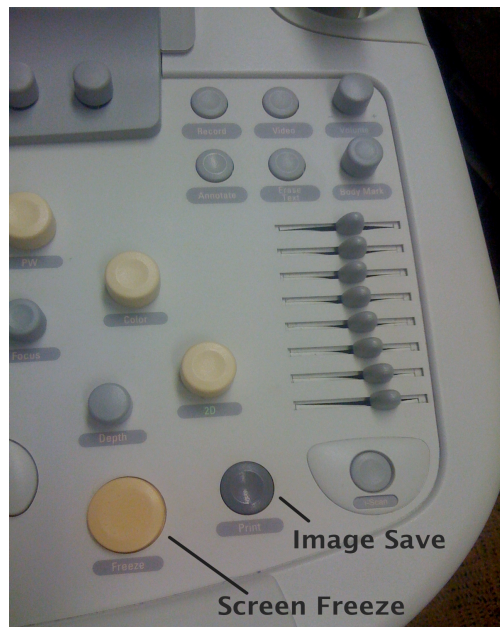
Ultrasound buttons used during image capture
